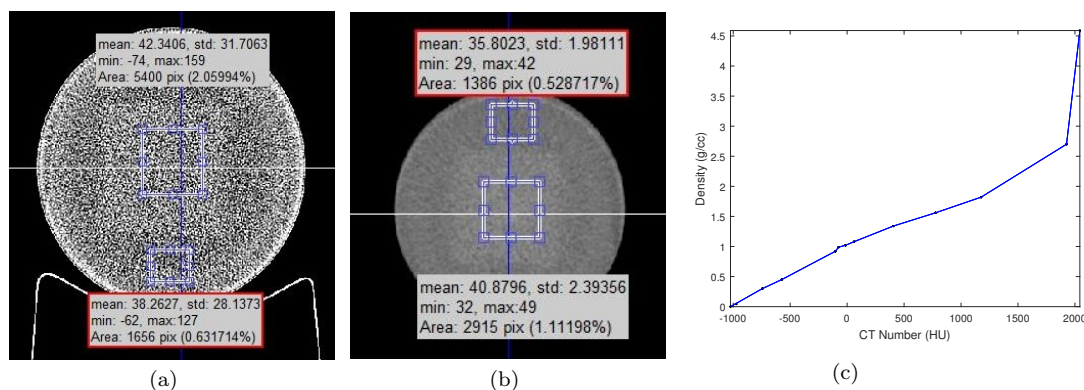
CT Image of (a) nMAG , (b) MAGAT and (c) the ramp used to convert CT values to density.
